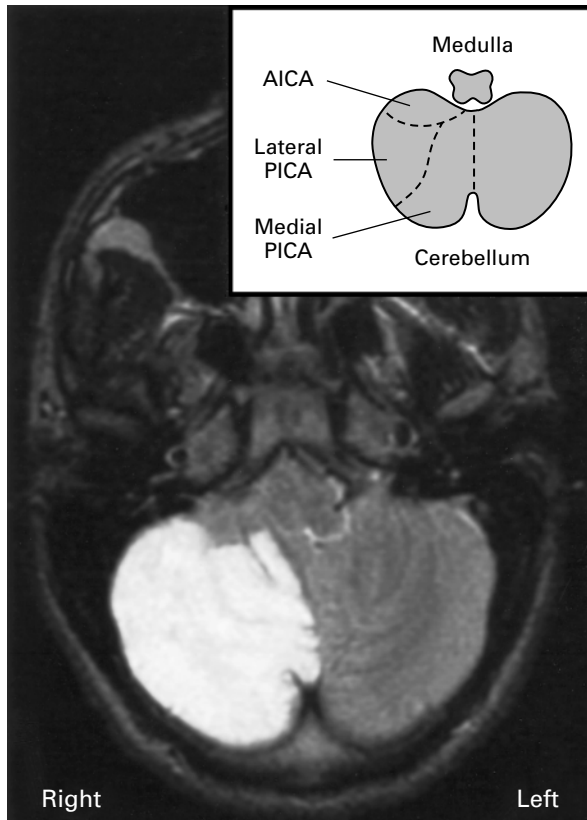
Magnetic Resonance Image of a Right Inferior Cerebellar Infarction in a Man with Acute Vertigo, Vomiting, Nystagmus Elicited by Right, Left, or Upward Gaze, and Severe Gait Instability.
